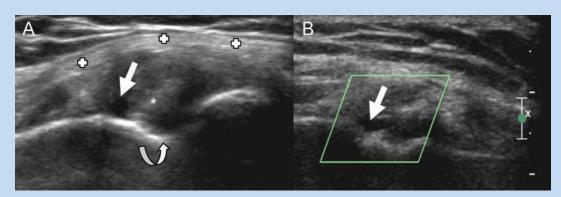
(A) Long axis grayscale ultrasound image along the lateral aspect of the knee demonstrates a small anechoic structure (straight arrow) within the anterior margin of the popliteus tendon (asterisks), reflecting a ganglion cyst. Curved arrow indicates popliteus sulcus of the femur; crosses indicate fibular collateral ligament. (B) Power Doppler image demonstrates no internal flow within the cyst (straight arrow), confirming that it is not a vessel.
